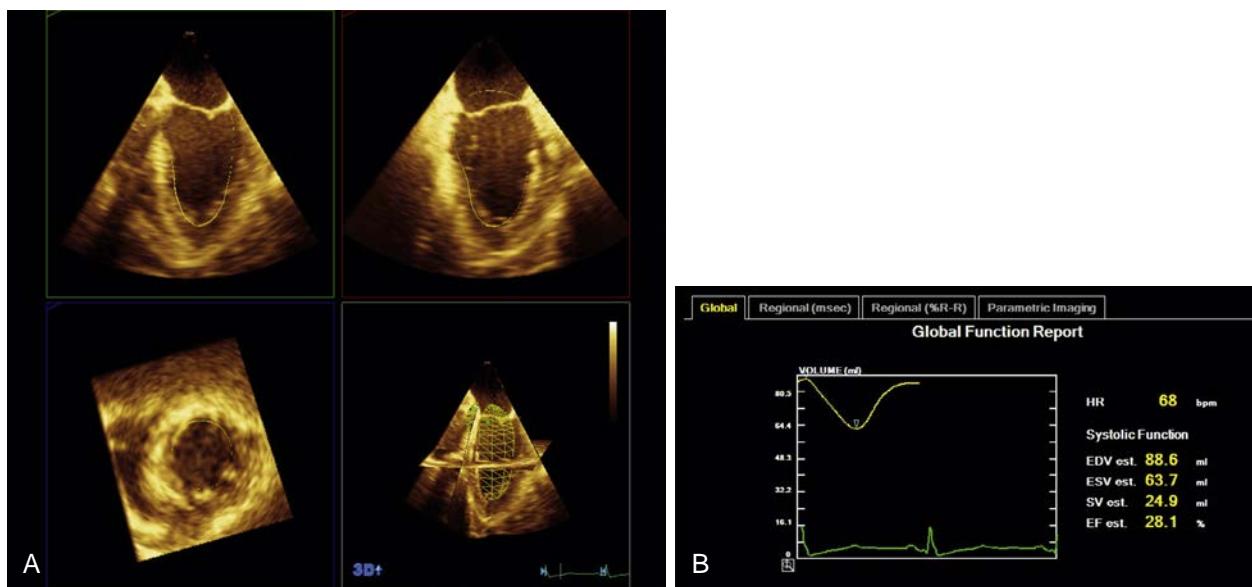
Three-dimensional (3D) transesophageal echocardiographic measurement of left ventricular ejection fraction. (A) A full-volume data set of the left ventricle is displayed using multiplanar reconstruction. After manual tracing of the endocardial borders at end-diastole and end-systole in the planes displayed in the top two panels, a semi-automated endocardial border detection algorithm tracks the borders in the remaining frames. (B) The yellow line displays the left ventricular volume over the duration of the cardiac cycle. Measurements reported include end-diastolic volume, end-systolic volume, stroke volume, and ejection fraction. Segmental changes in volume over the course of the cardiac cycle can also be displayed.
